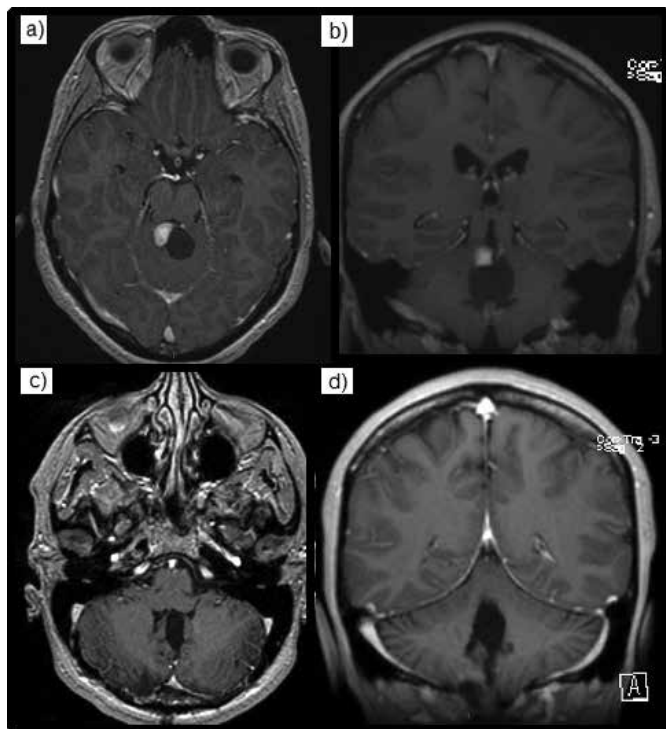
MRI of cerebellar hemangioblastoma: a-b: pre-op; c- d: post-op.
